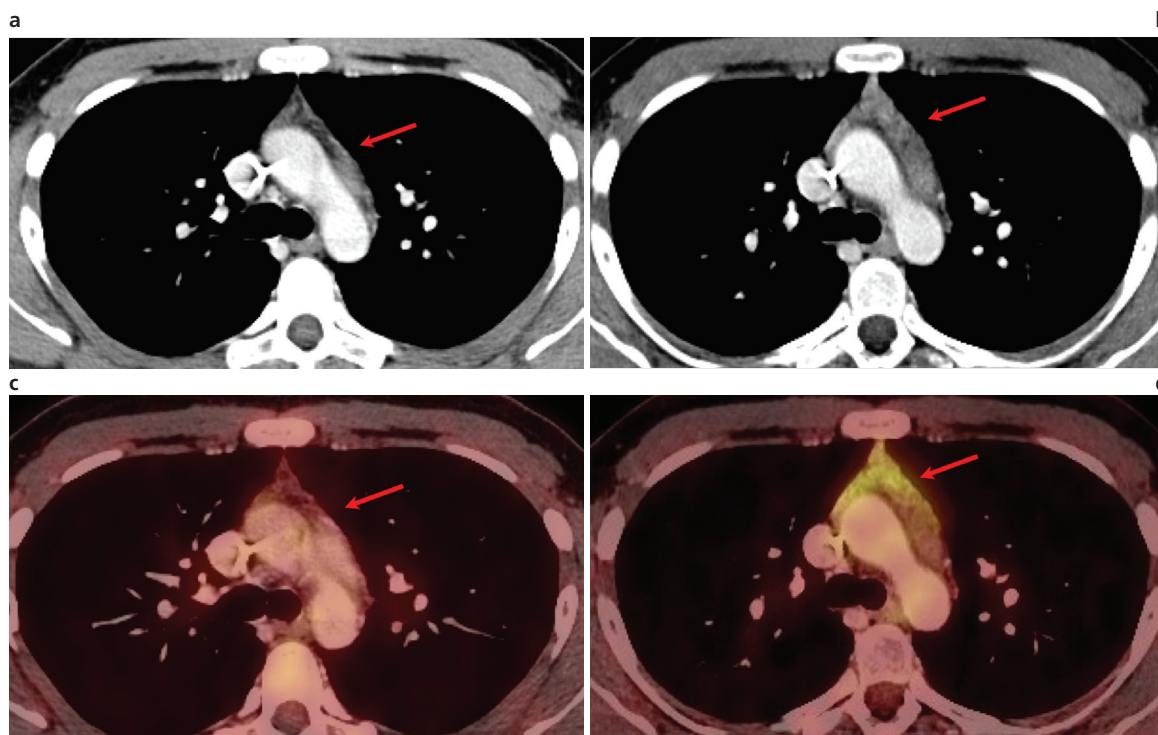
Rebound hyperplasia. Axial IV contrast-enhanced CT (A and B) and PET-CT fusion imaging (C and D). Twenty-one year-old male patient who underwent chemotherapy for testicular tumor. Pre- (A and C) and post- (B and D) chemotherapy images revealed a slight enlargement of the thymus and significantly increased F18-FDG uptake (SUVmax: 3.8). The lesion was diagnosed as rebound thymic hyperplasia. The patient continues with no changes after two years of follow-up.
